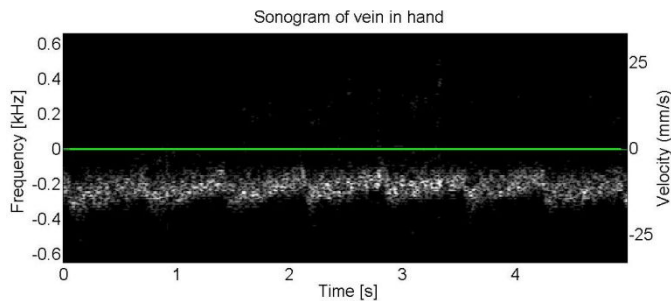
Pulsed-wave Doppler waveform of a vein in the back of a human hand.
